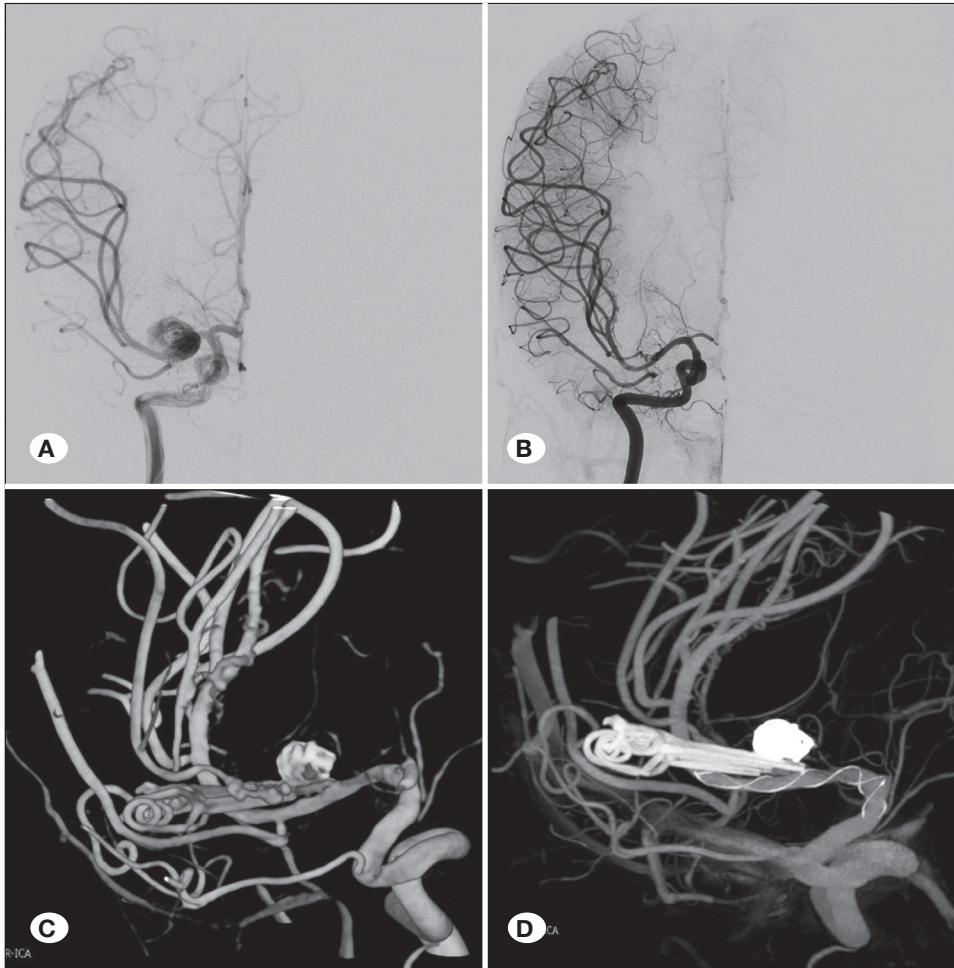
A) Intraprocedural angiogram reveals the contrast stasis within the aneurysm. B) The 11-month follow-up digital subtraction angiography (DSA). C) A reconstructed 3D image from DSA. D) Vaso CT.
